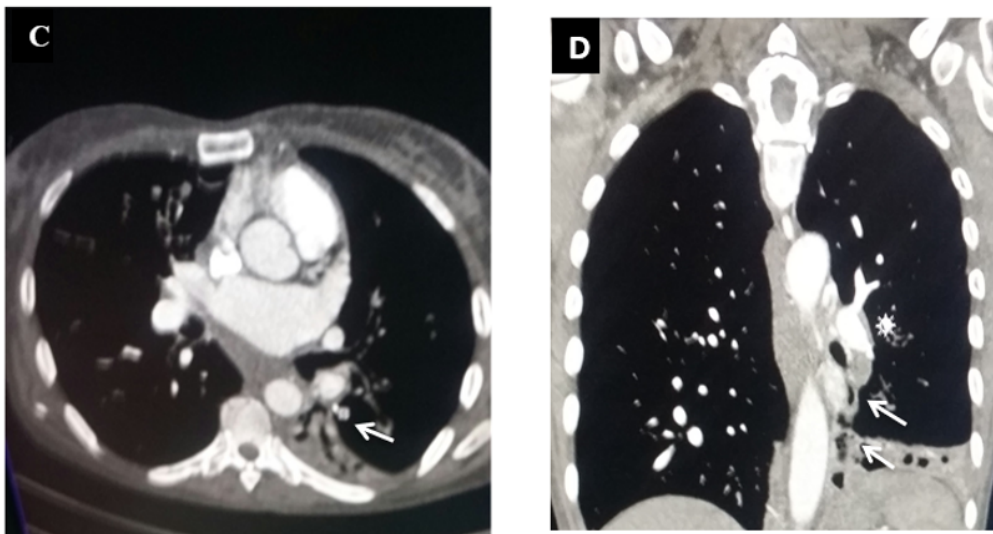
Control thoracic CT angiography, performed in the aortic phase and the pulmonary artery phase (mediastinal window), axial slice (C), same section plane as figure 1B for a perfect comparison: disappearance of the gap in the left lower lobe artery (arrow). Coronal slice (D): aorto-pulmonary anastomosis with passage of systemic blood flow into the pulmonary circulation (arrow).
